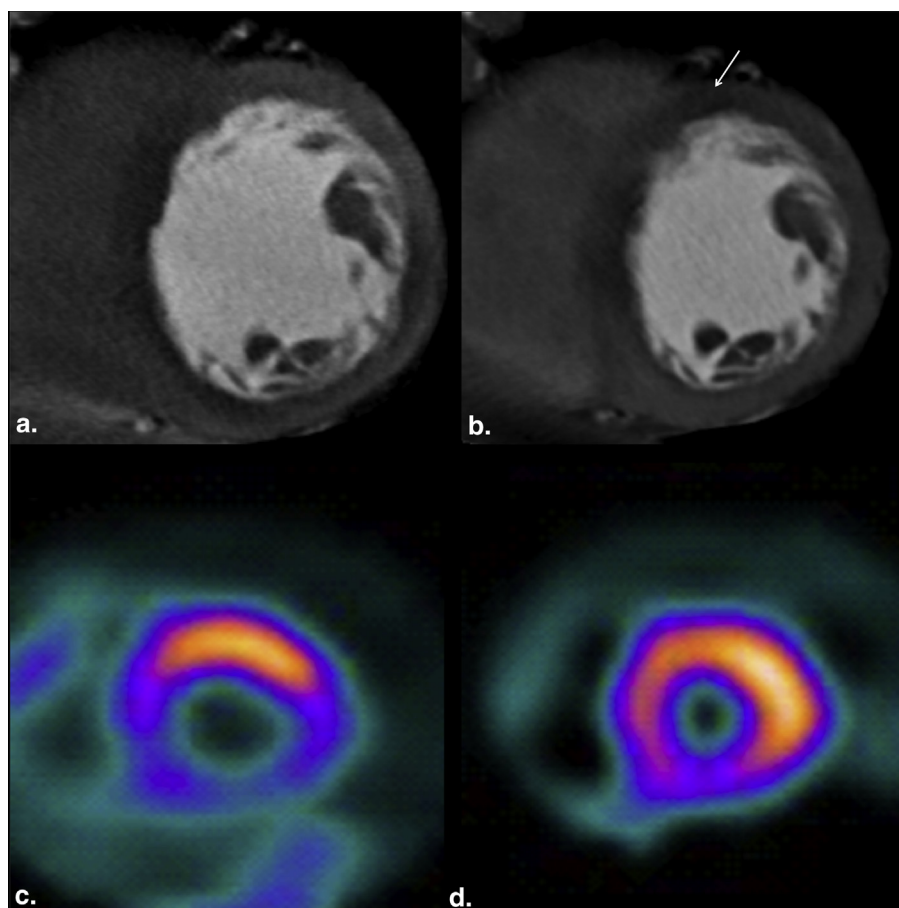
Example of beam-hardening artifact (BHA) with single-energy computed tomography (SECT). Stress (*panels a and c*) and rest (*panels b and d*) short-axis views of SECT (*above*) and single-photon emission computed tomography (SPECT, *below*). Inferior and inferoseptal wall reversible defect (ischemia) is observed with both approaches. A BHA can be recognized as a significant myocardial signal density drop resembling a perfusion defect at the anterior wall in rest (*arrow*), with normal perfusion both at stress and with SPECT.
